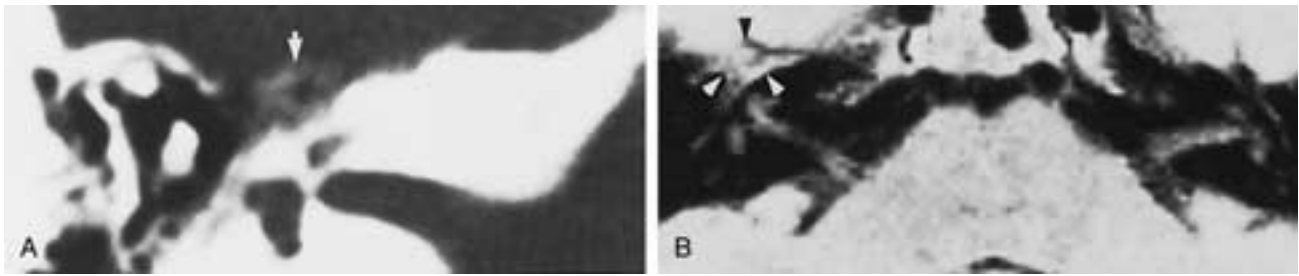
Geniculate intratemporal vascular tumor. A, Axial CT. Note the characteristic “honeycomb” bone (arrow). Bone interspersed within the tumor tissue is less dense than adjacent normal bone. B, Proton density image. Note the heterogeneous hyperintensity in the geniculate fossa and the surrounding region (arrowheads) adjacent to the temporal lobe. (From Lo WWM, Shelton C, Waluch V, et al. Intratemporal vascular tumors: detection with CT and MR. *Radiology* 1989;171:443–448.)
